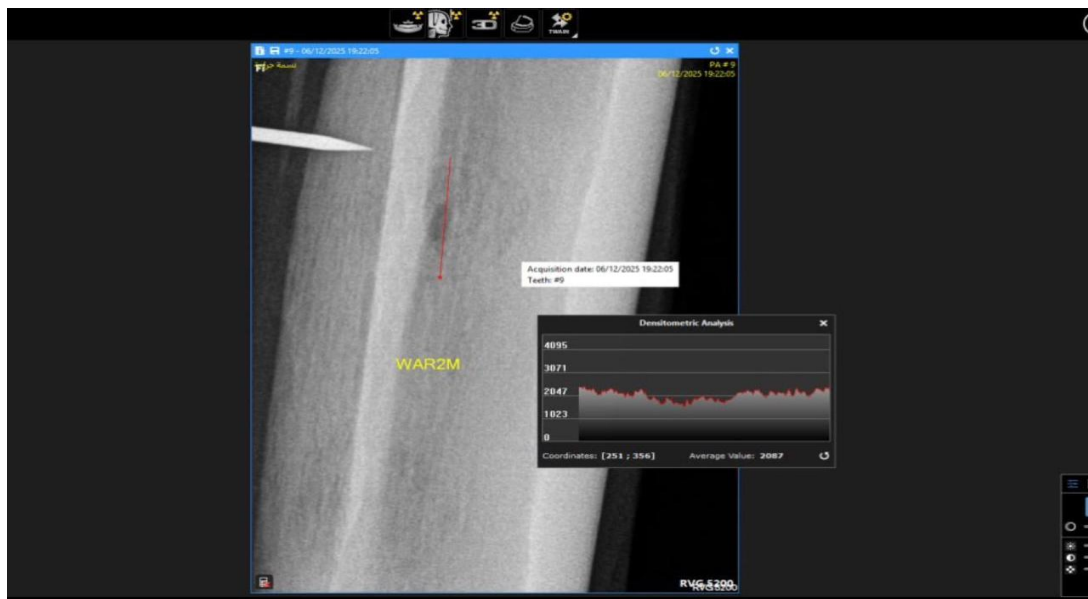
Radiographic densitometric screenshot labelled WAR2M, showing a longitudinal measurement field with an average value of approximately 2087.
